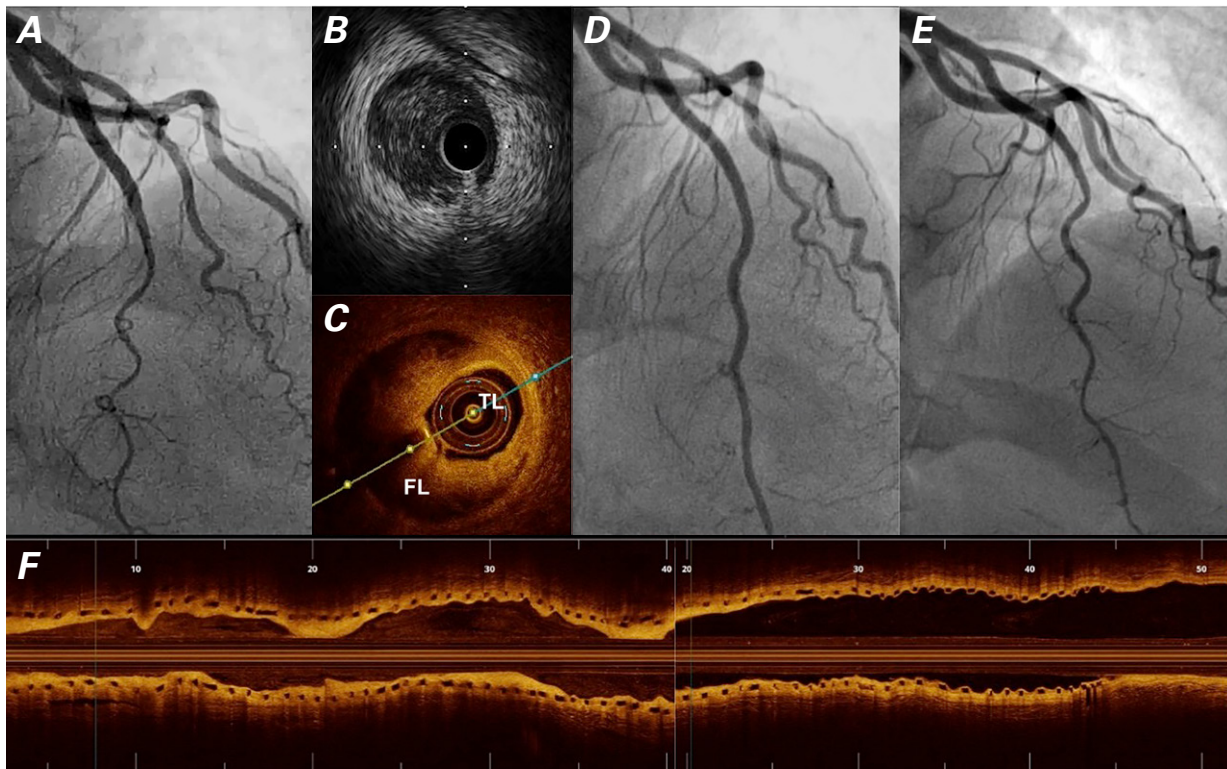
Patient 1. A) Angiogram shows type 2 spontaneous coronary artery dissection from the mid to the distal segment, confirmed by an B) intravascular ultrasonogram and an C) optical coherence tomogram (axial view) showing the dissection with a true lumen (TL) compressed by an extensive false lumen (FL) filled with intramural hematoma. D) Angiogram shows immediate straightening of all bends in the artery after implantation of 3 overlapped bioresorbable scaffolds. E) Angiogram after one year shows the healed vessel with its structure restored. F) Optical coherence tomogram (long view) shows results at one year.
